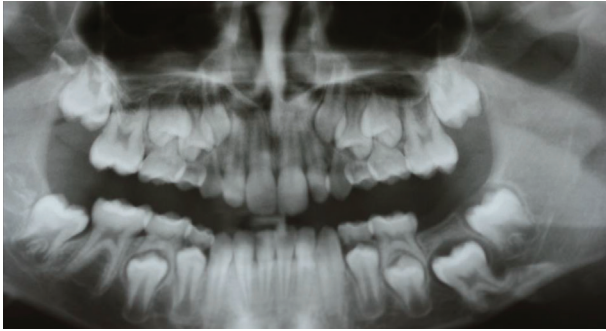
Panoramic radiograph of a 9-year-old patient in early mixed dentition showing an impacted lower left first molar (tooth 36) with roots positioned near the inferior border of the mandible. The distal root is dilacerated.
